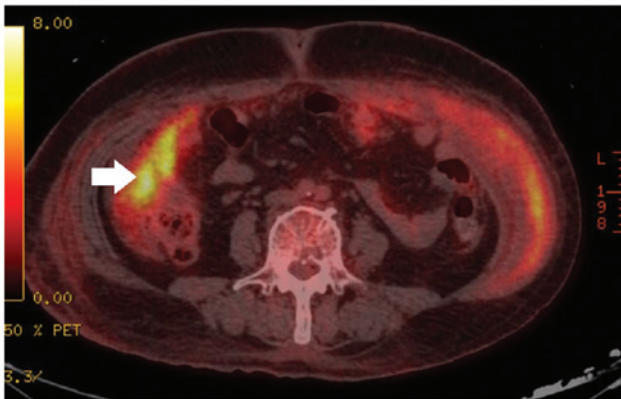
Positron emission tomography/computed tomography findings. The white arrow indicates hot uptake in greater omentum.
